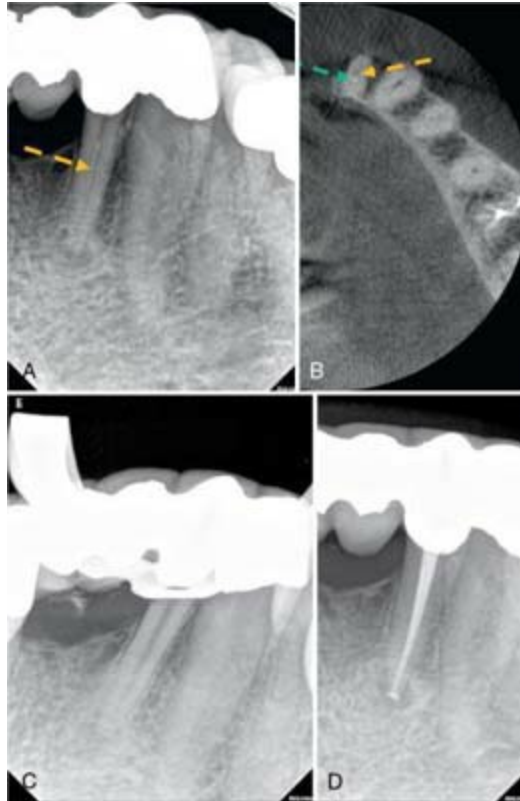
Unexpected torsional and flexural failure of endodontic instruments can occur during instrumentation. A, PA radiograph shows a separated file (*yellow arrow*) located at the midroot of the mandibular left lateral incisor in a patient referred for revision treatment. B, To aid development of a retreatment strategy, CBCT was used to localize the instrument (*yellow arrow*) in the lingual canal, with identification of the buccal canal (*green arrow*) to facilitate bypassing the instrument and (C), subsequent removal. D, Obturation was completed without complication.
